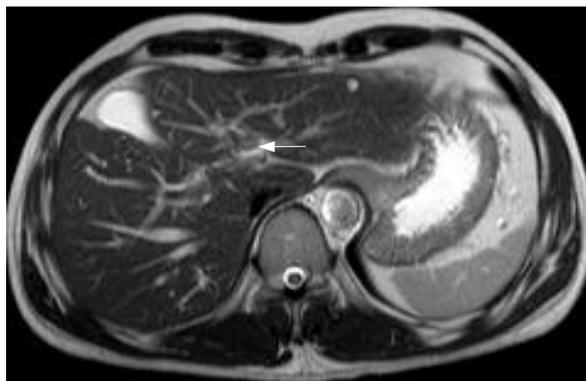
MRI T2 imaging showing a thrombus in the left portal vein.
